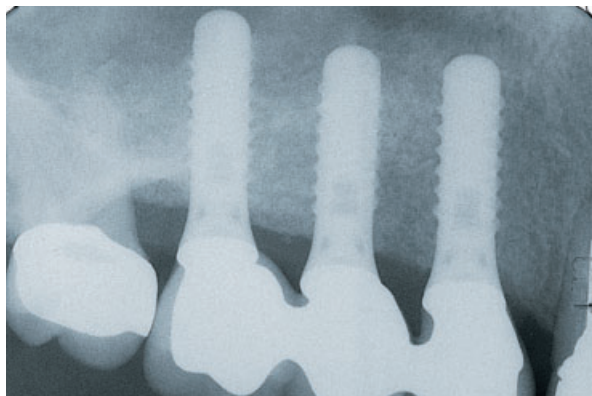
Five-year follow-up radiograph of the same quadrant, now restored with a three-unit transverse screw-retained metal-ceramic implant suprastructure. Note that the distal retainer of the original tooth-borne FPD could be maintained.
